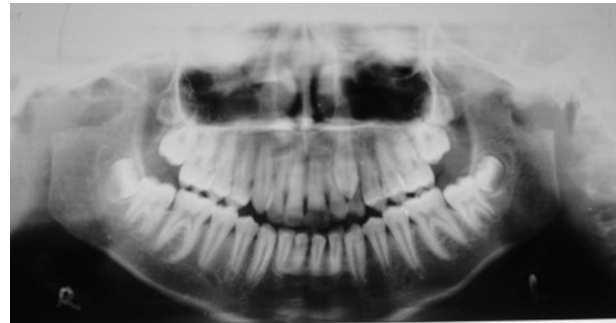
Immediate postoperative orthopantomogram.
